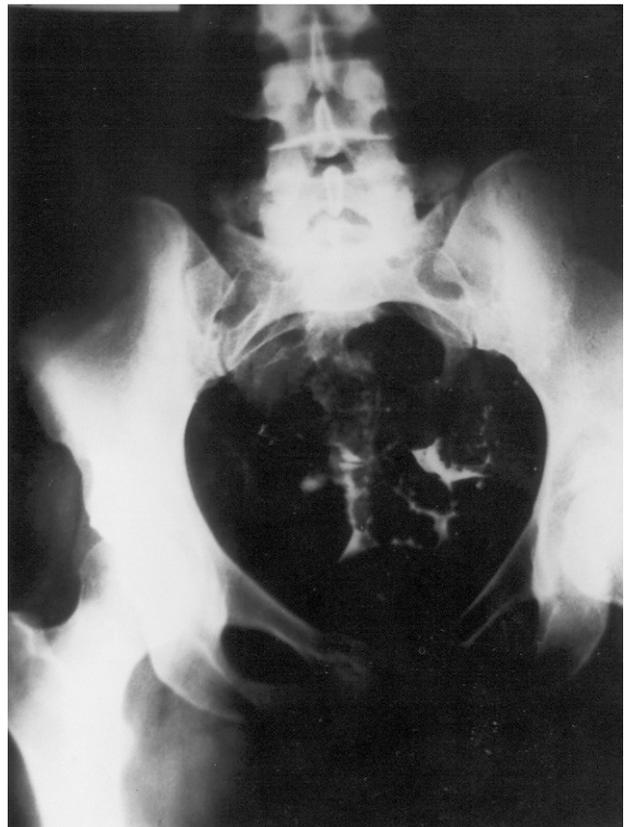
Control X-Ray 24 hours after Lipiodol administration.
